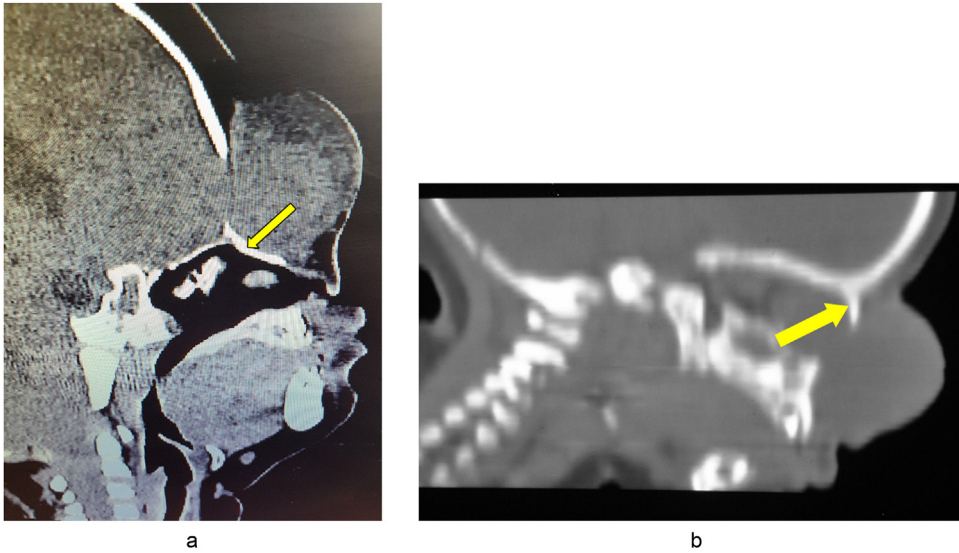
a. CT scan of supranasal encephalocele showing nasal bone displacement. b. CT scan of infranasal encephalocele showing nasal bone displacement.
